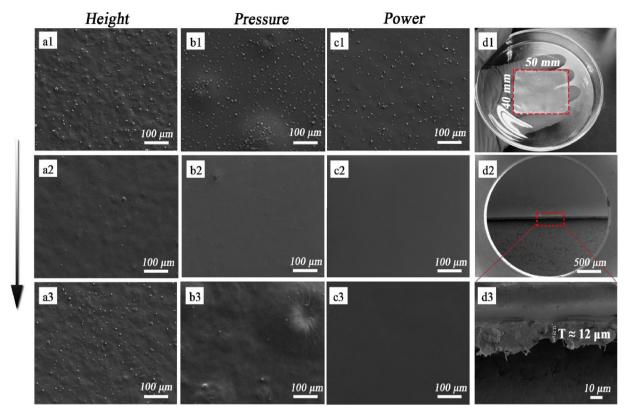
The images of films morphology. By adjusting the preparation parameters: (a) height, (b) gas pressure, (c) ultrasonic power, (d) obtained film morphology and thickness.
